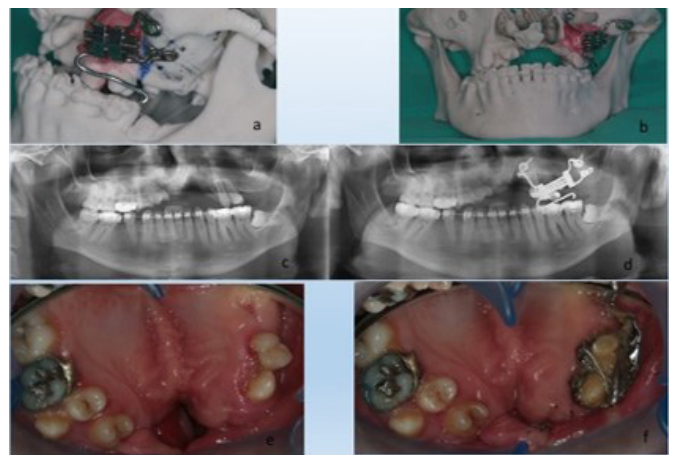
Patient's 3D casts, pre and post-operative radiographs and intraoral images
